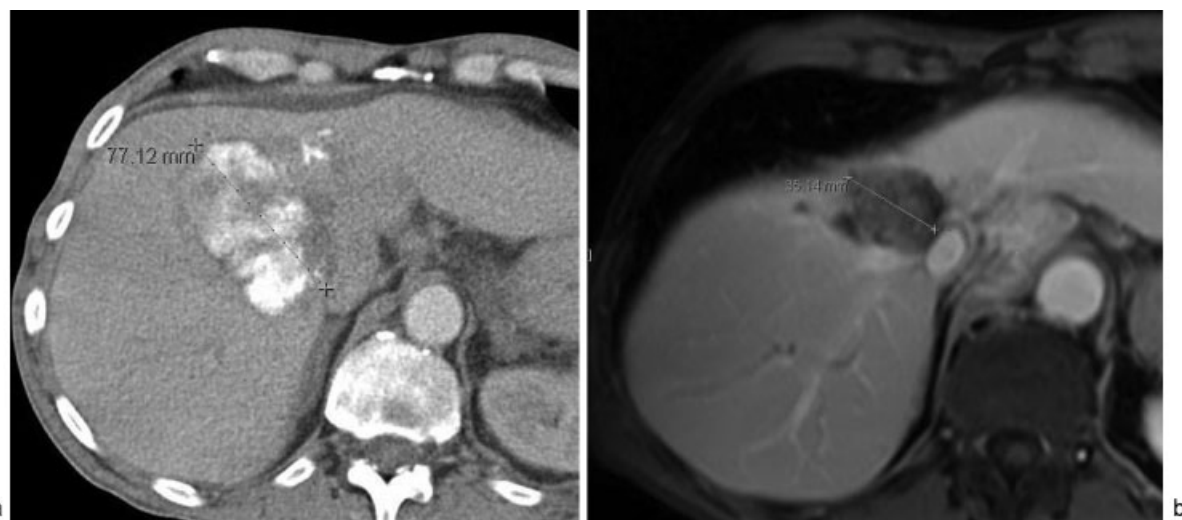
Chemoembolization of intrahepatic cholangiocarcinoma (ICC). (a) CT 1 month after transarterial chemoembolization shows dense lipiodol retention in a 7.7-cm ICC. (b) MRI at 30-month follow-up shows no residual enhancement and a 50% reduction in tumor diameter.
